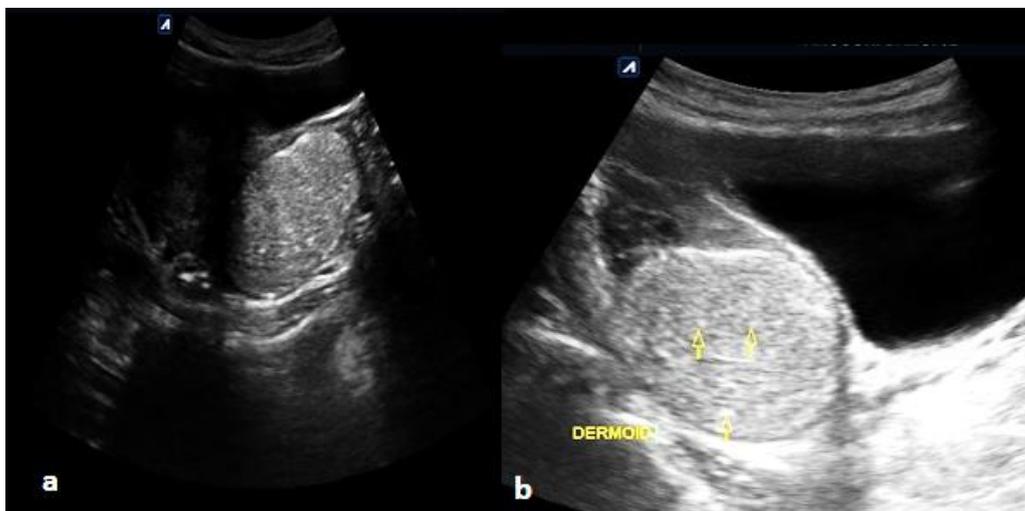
(a) (b)- Greyscale ultrasound of the pelvis shows a well-defined lobulated mixed echogenicity lesion with posterior acoustic enhancement and multiple thin linear echogenic bands representing hair in the cyst cavity (arrow).
